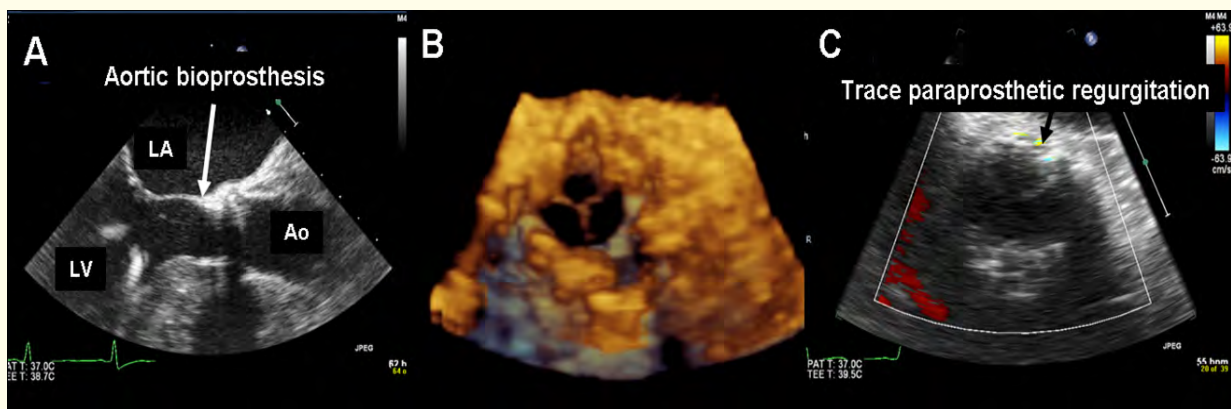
Intra-procedural echocardiographic assessment of the bioprosthetic valve position and function. Immediately following the valve deployment, transesophageal echocardiogram demonstrated optimal valve position (A), normally functioning leaflets demonstrated on 3D images from the short axis view (B) and a trivial paraprosthetic leak on color Doppler (C).
